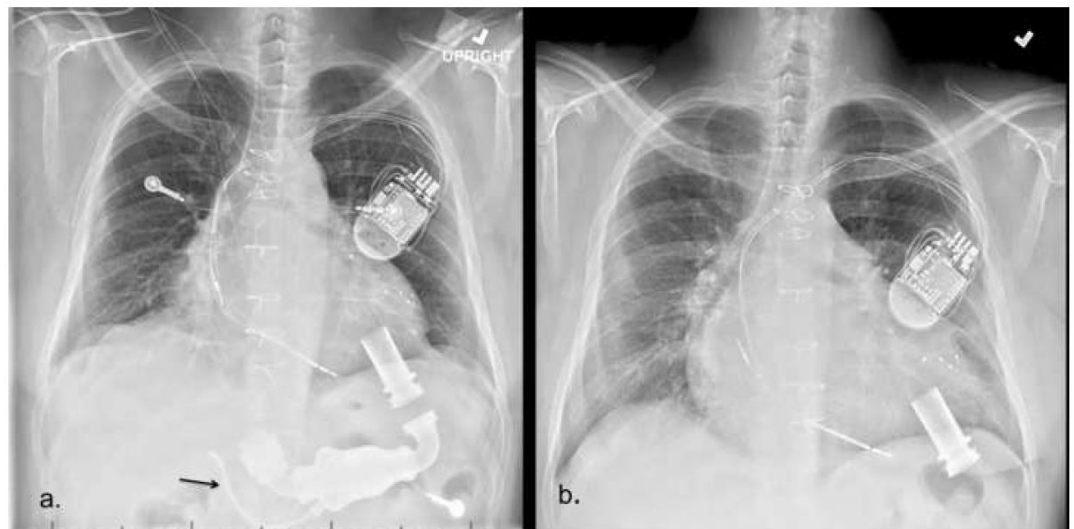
(a) Chest x-ray with Heartmate II driveline remnant (arrow). (b) Chest x-ray after Heartmate II explant.
